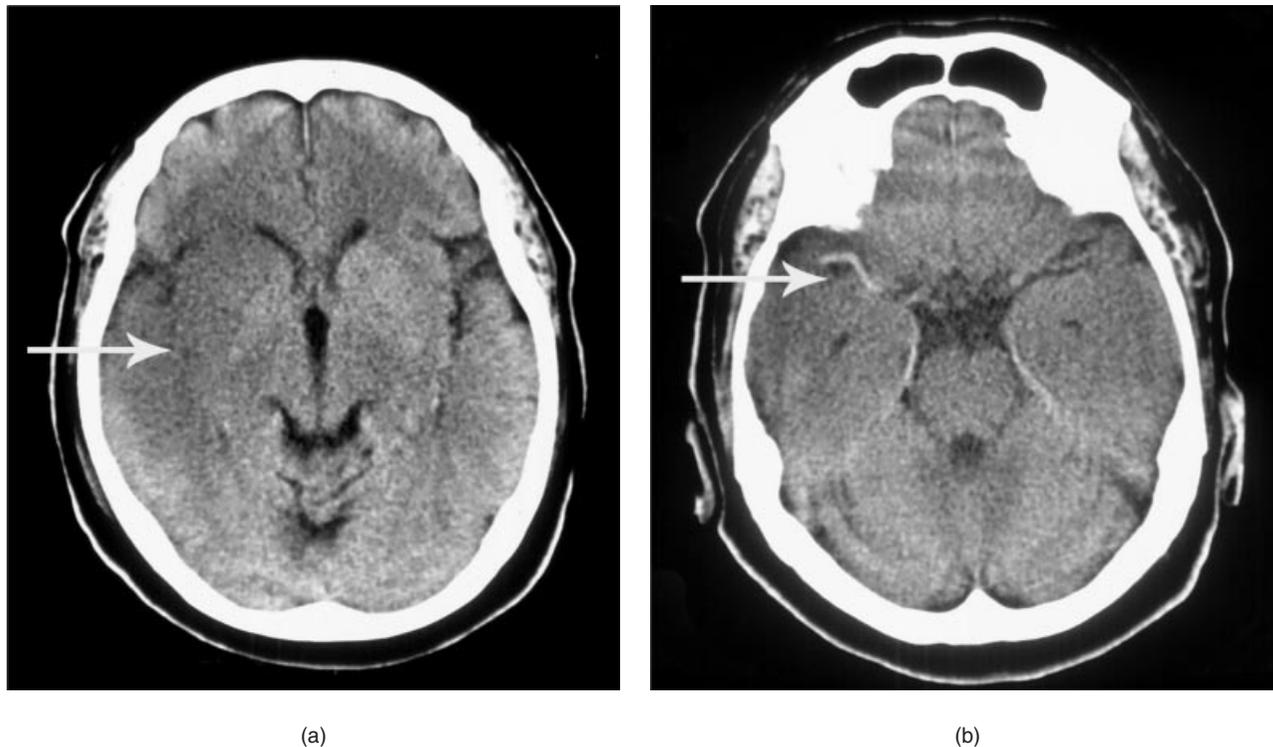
(a) Early changes of right MCA territory infarction on CT scan. (b) MCA hyperdensity in the same patient.
